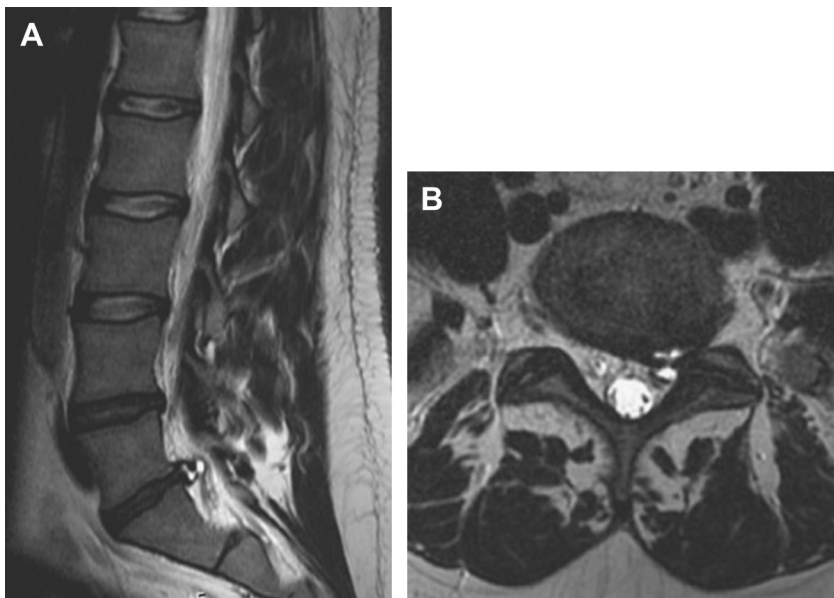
Case example. The patient is a 23-year-old man presenting with signs and symptoms consistent with a left S1 radiculopathy. MRI of the lumbar spine demonstrates a left herniated disk at L5-S1, shown on (A) parasagittal and (B) axial images. After failing conservative management, he is taken for elective left L5-S1 minimally invasive microdiscectomy.
